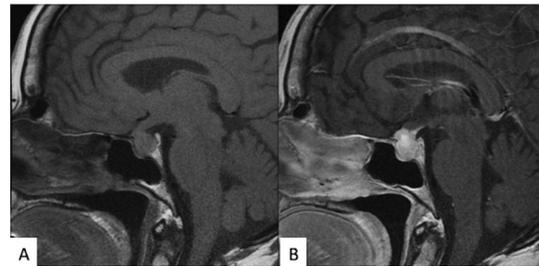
Pre-contrast (A) and post-contrast (B) T1-weighted sagittal pituitary magnetic resonance images demonstrated a mass located mainly in the sellar cavity and extending to the suprasellar cistern with heterogenous contrast-enhancement while normal pituitary tissue is indistinguishable.
